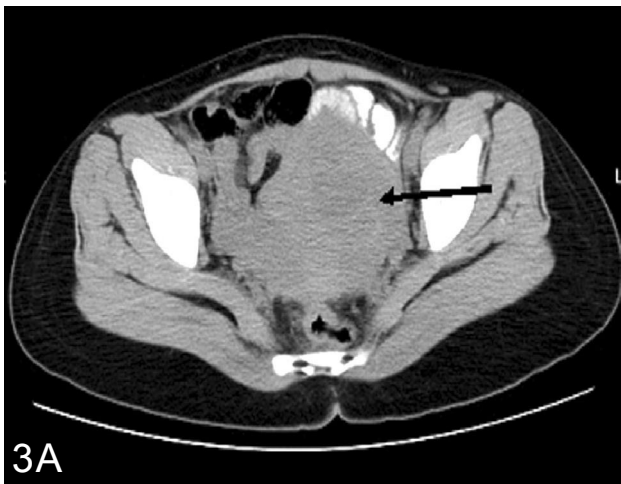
Unenhanced CT image showing a bulky uterus with ill-defined uterine mass, arrowed (A). On contrast injection there were multiple vessels within the mass and prominent left pelvic vessels, arrowed (B). Volume rendered image that shows the UAVM vasculature, arrowed (C).
